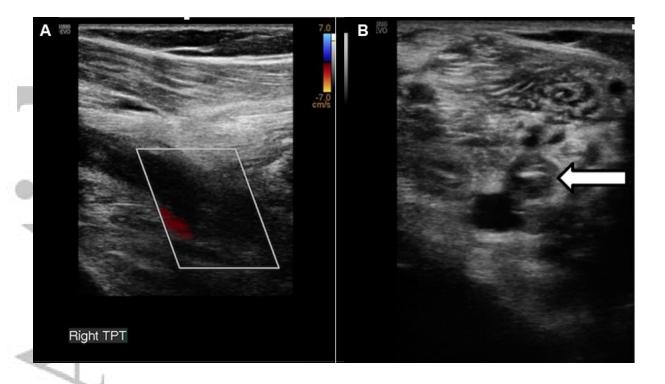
Imaging from Patient 2. Panel A is a Doppler ultrasound image showing a longitudinal section through the right popliteal vein, with no blood flow demonstrated. Panel B is a transverse section showing echogenic material in the vein.
